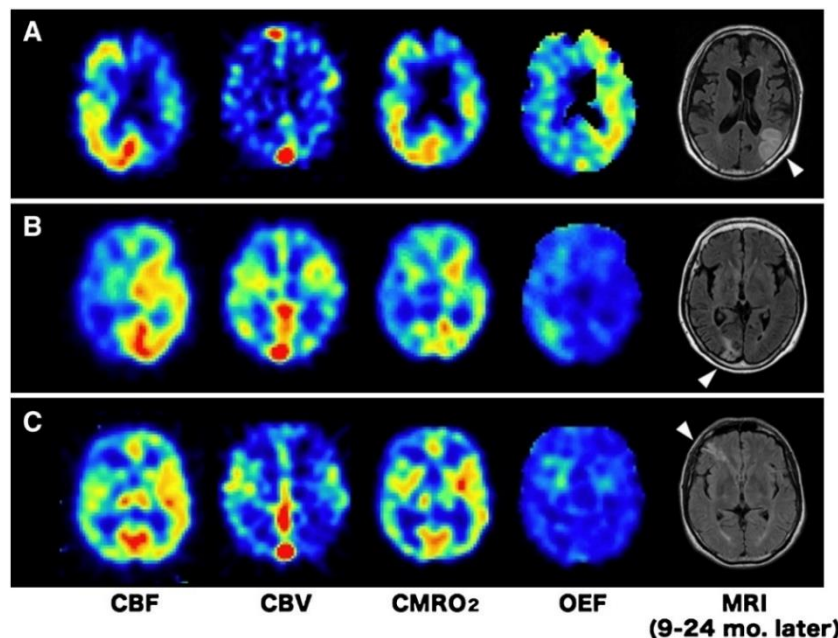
Increased OEF in patients with carotid artery occlusion. CBF, CBV, CMRO₂ and OEF measurements with [¹⁵O]-PET from three patients (A-C) with occlusive carotid artery disease in which hypoperfusion led to compensatory increases in OEF. In these examples, ipsilateral infarctions (arrows) were observed in follow-up magnetic resonance images near regions of increased OEF. In these images, cold colours (blue) indicate low values, while warm colours (red) indicate high values. This figure was reproduced from Hokari *et al.* (2009), *Surgical Neurology*,³¹ with permission provided by Elsevier and Copyright Clearance Center.
